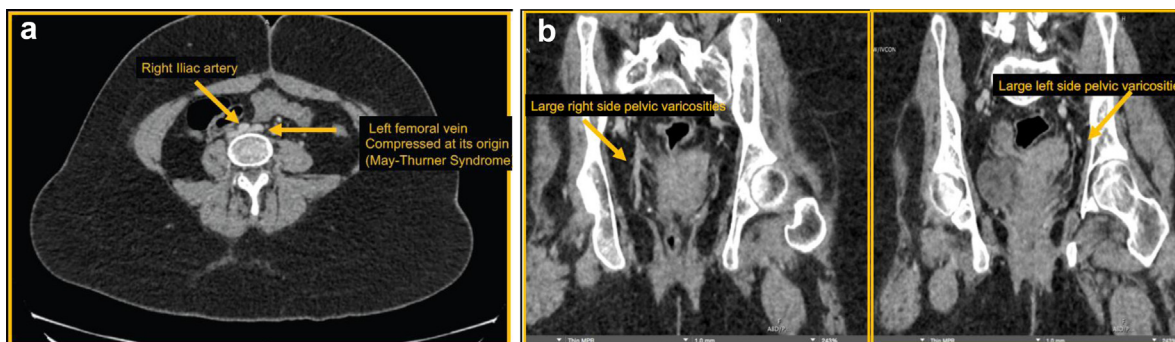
Computed tomography venography demonstrating flattening/compression of left common iliac vein (CIV) origin by an over-riding right common iliac artery (a) and bilateral large pelvic varicosities (b).
